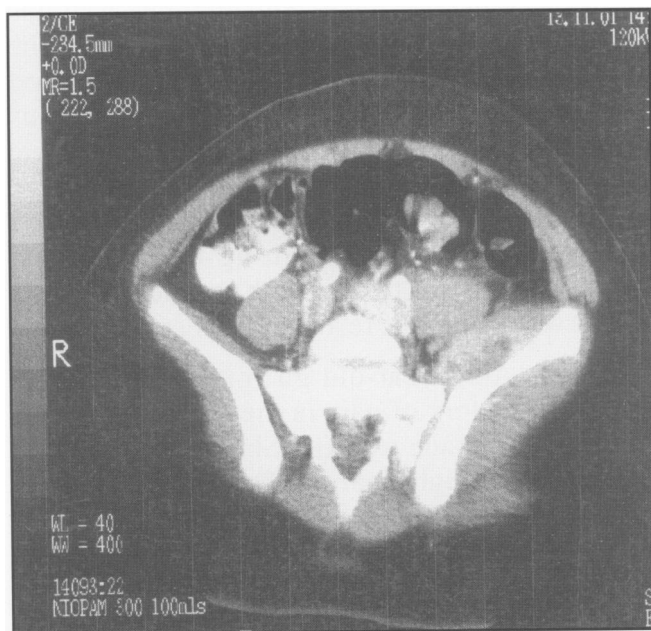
Contrast-enhanced CT scan of pelvis showing periosteal reaction left ilium and an iliacus abscess.
